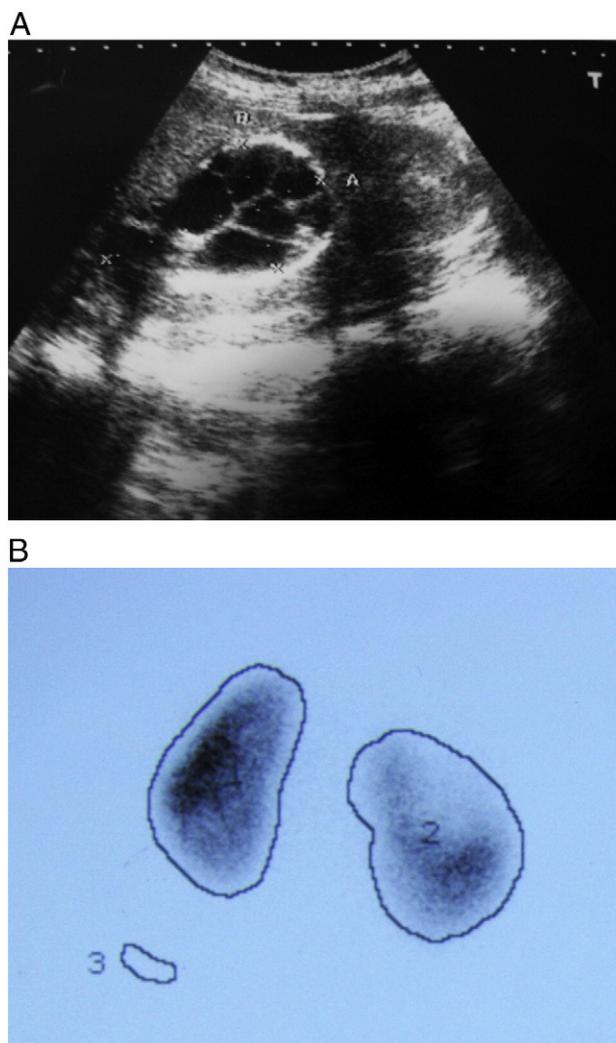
(A) Image of renal cyst at ultrasonography. (B) Image of renal cyst at scintigraphy.
